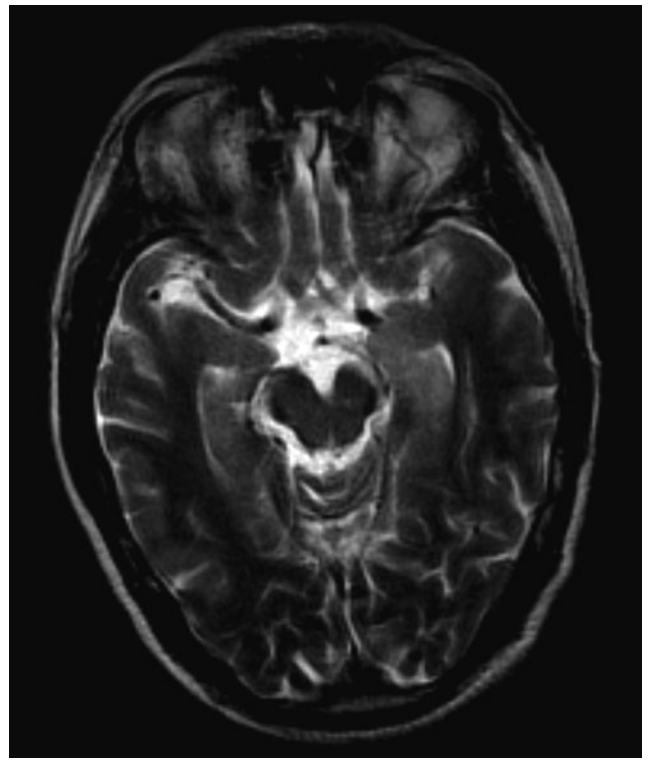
Magnetic resonance imaging T₂ image demonstrating increased signal in mesial temporal lobes.
